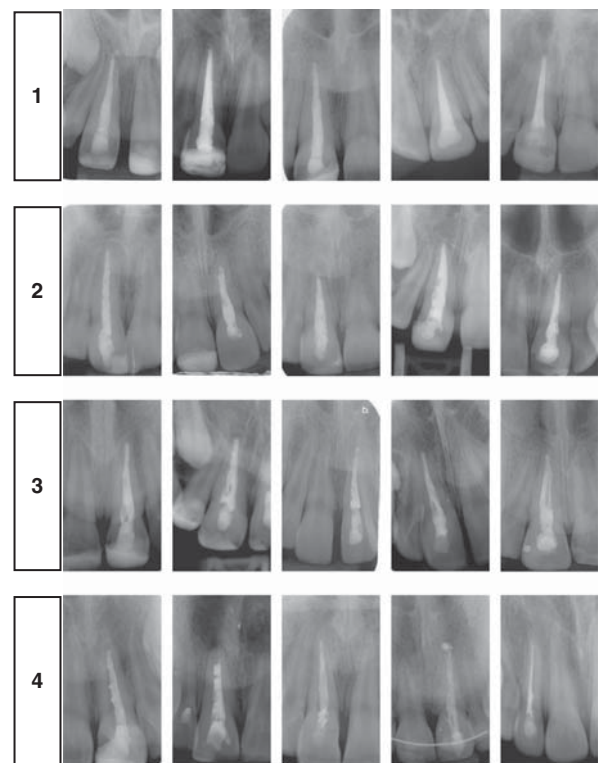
Scoring system for root filling quality. The experimental radiograph is compared with those of the references and assigned the score of the reference which it resembles the most.
